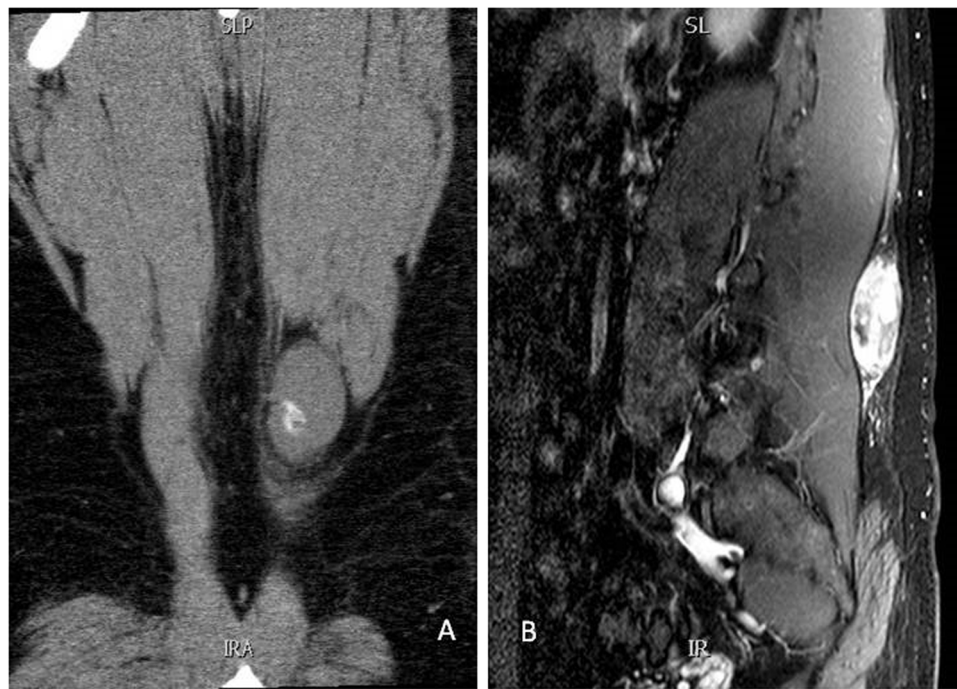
Magnetic resonance imaging coronal view (panel A) and sagittal view (panel B) showing clearly the lesion with some calcification.
